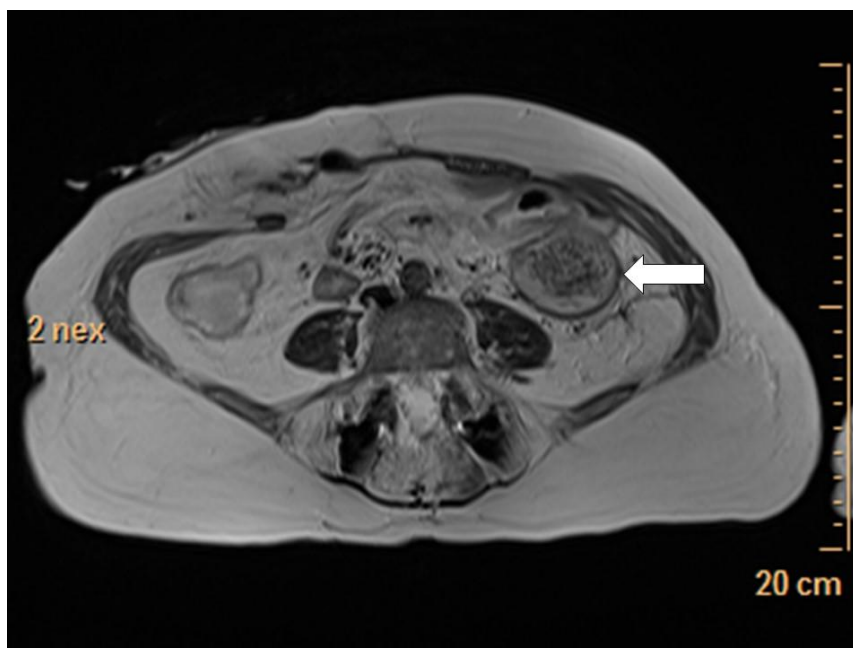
T2-weighted MRI image showed a well-encapsulated mass with low signal intensity capsule (white arrow) and spongiform low signal intensity within
